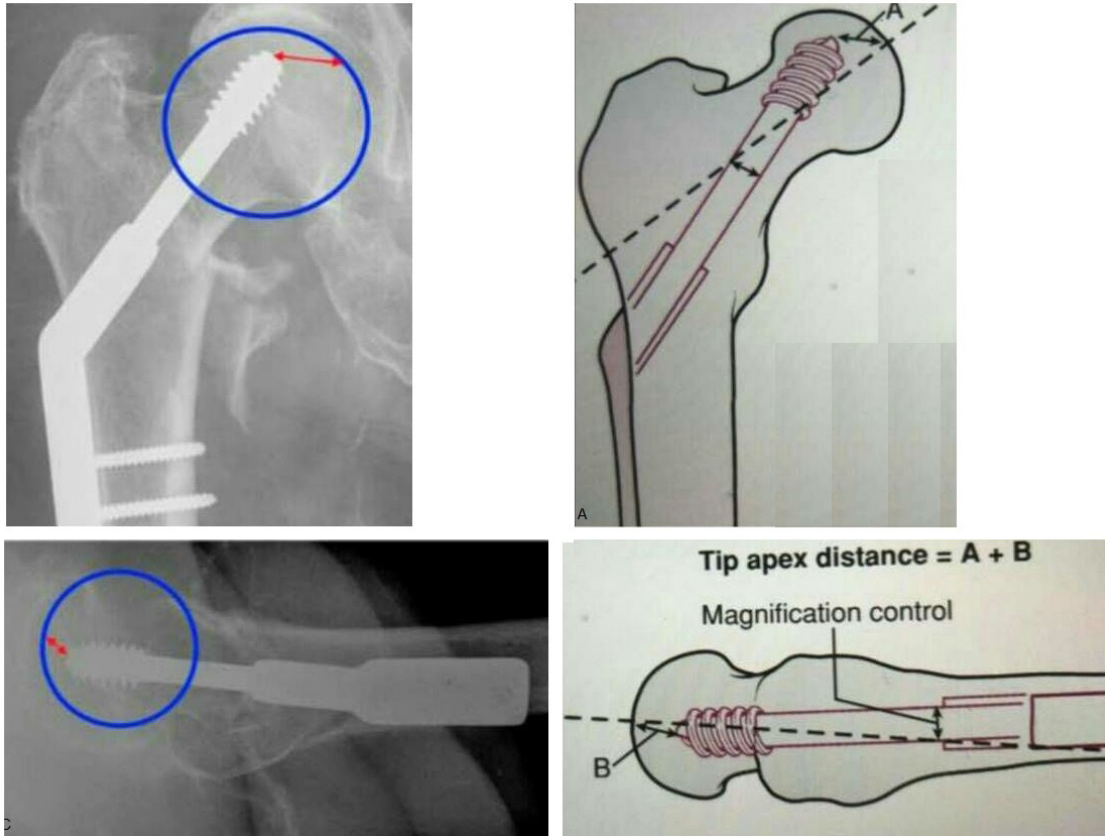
Measurement of the tip-apex index (A), which consists of the sum of the measurements of the anteroposterior and lateral radiographs. (B,C)
